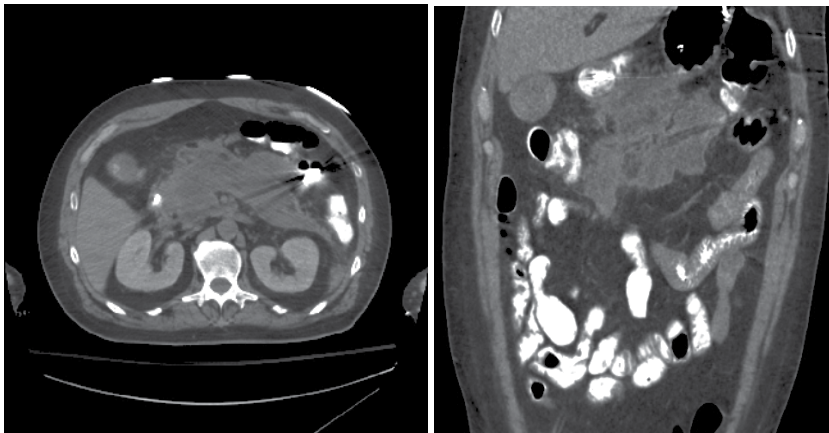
Abdominal CT of a patient who developed acute upper abdominal pain following aortic valve replacement surgery. Representative images of severe necrotizing pancreatitis are shown. Non-operative management resulted in resolution of pancreatitis approximately 2 weeks after the diagnosis was made.
